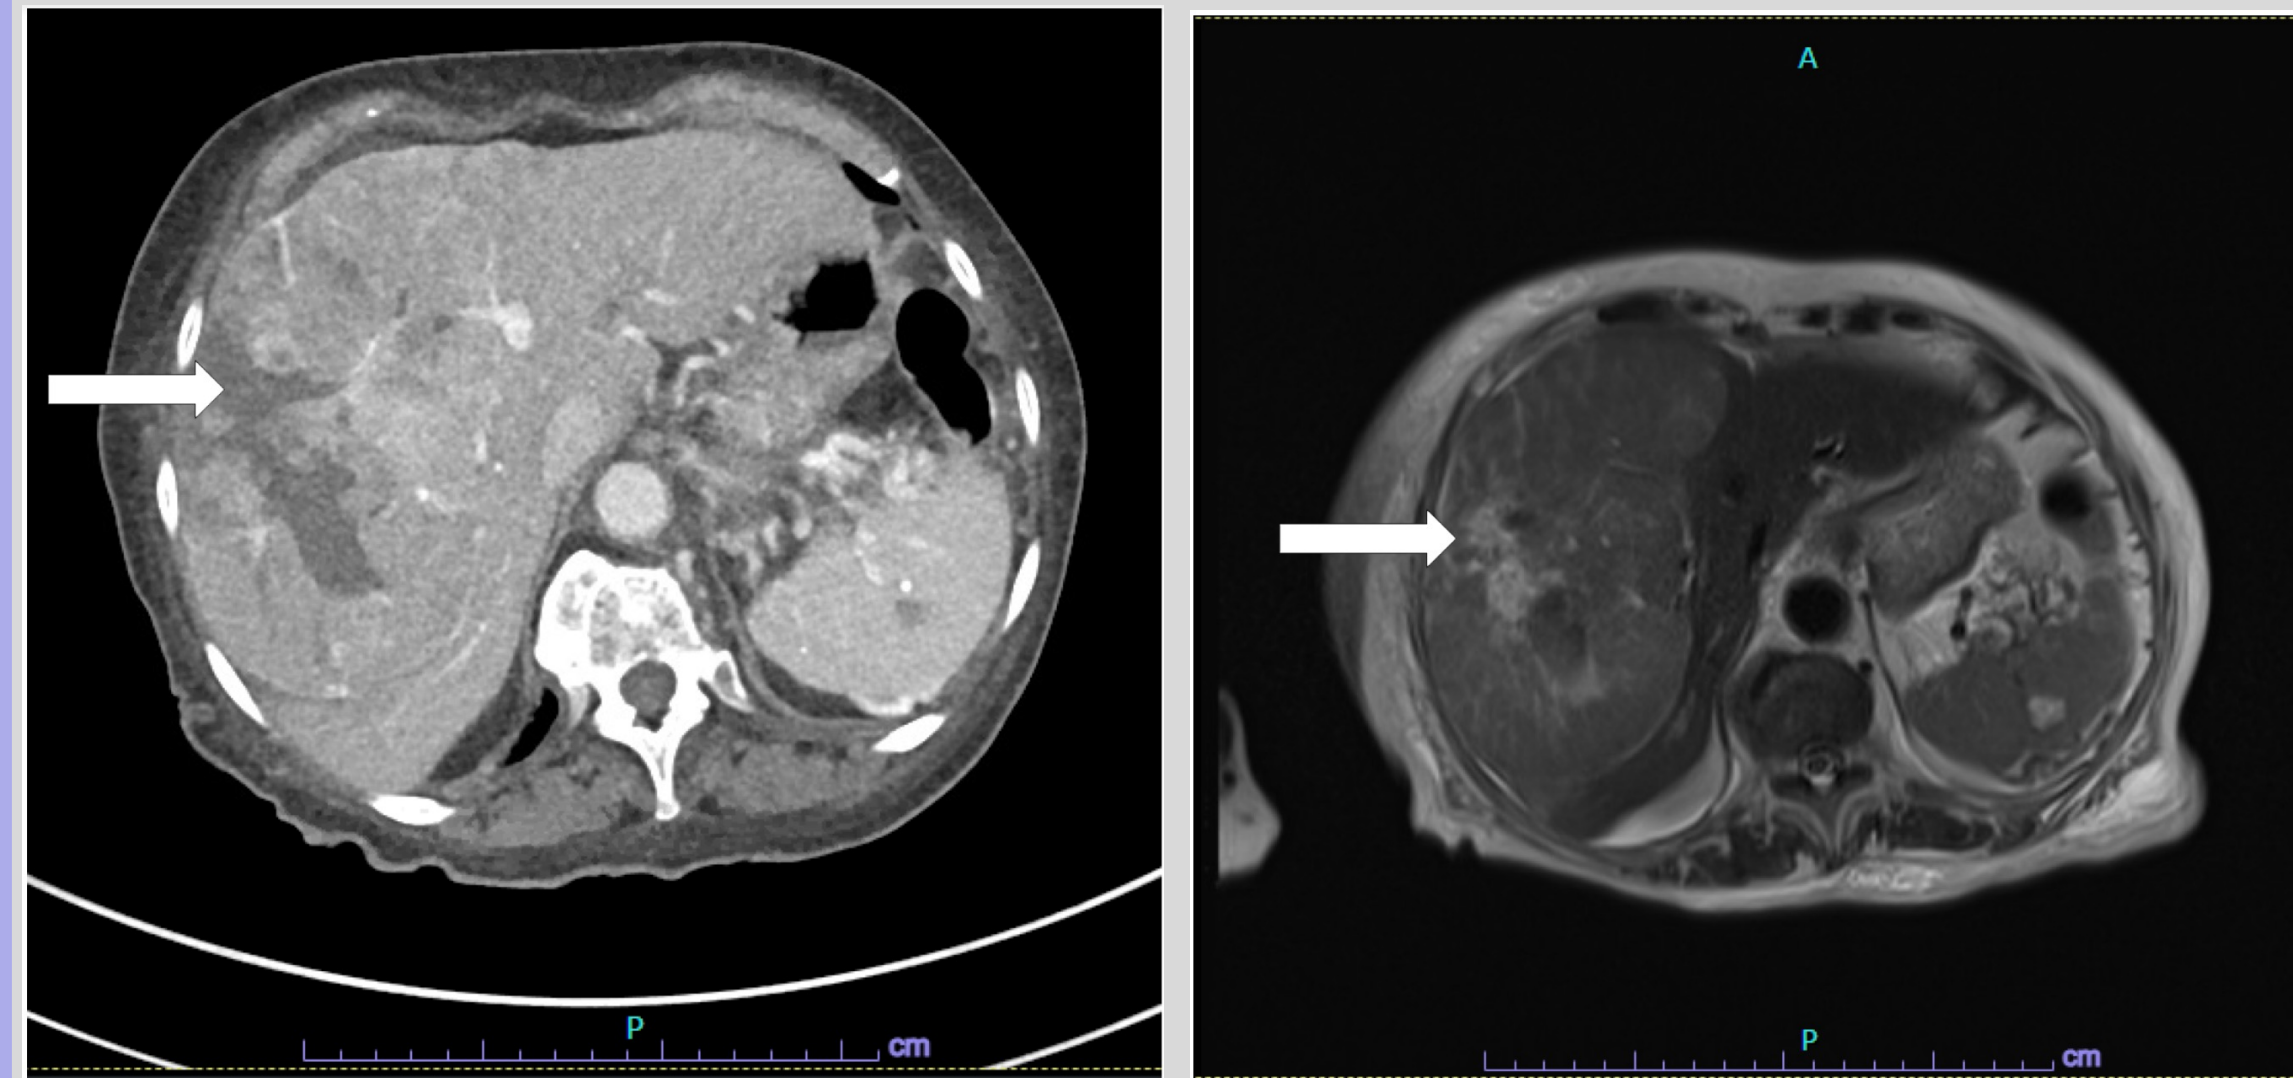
Transverse view of HCC occupying R hepatic lobe (CT w/ con)
